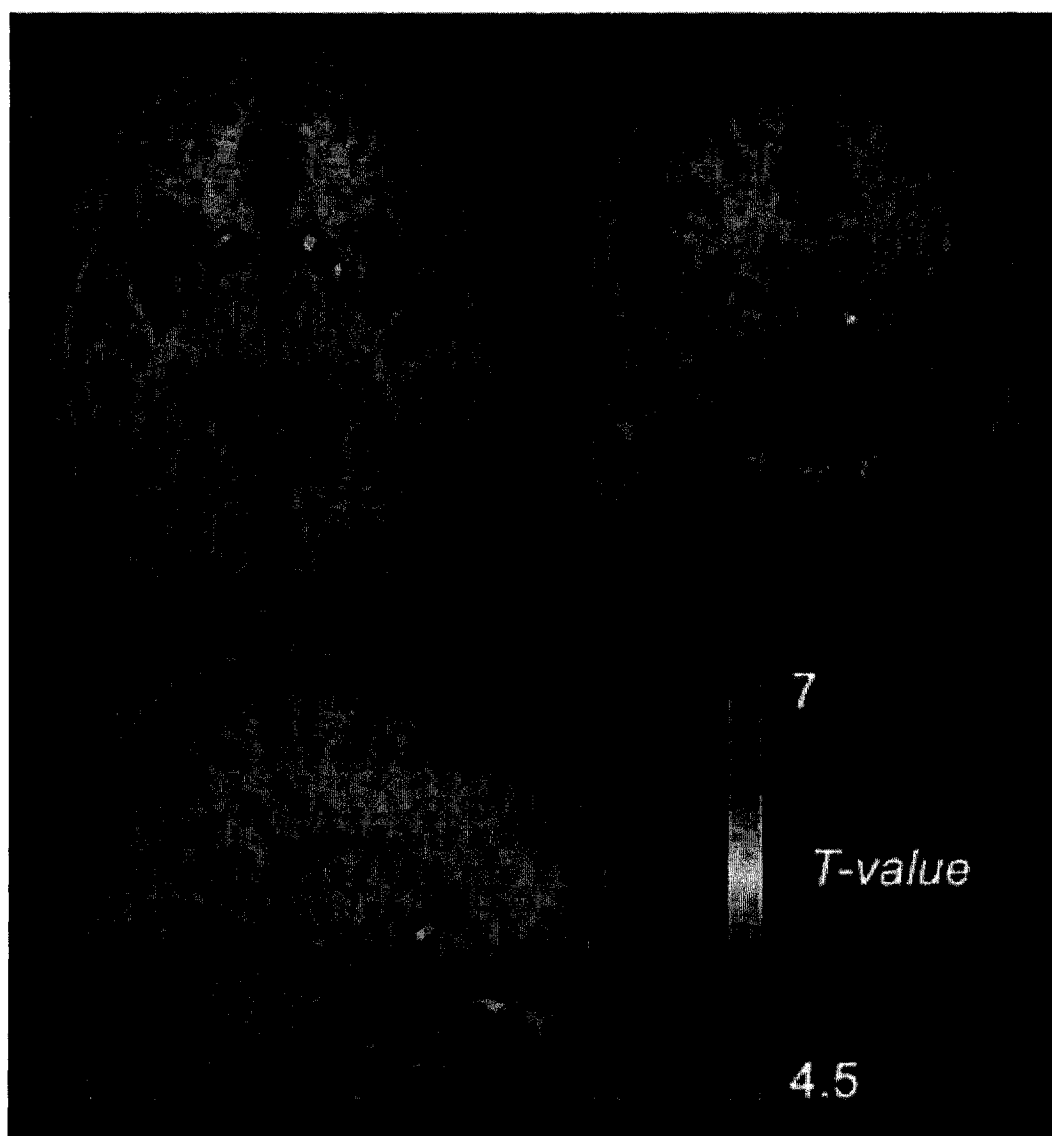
Statistical *t*-map of the change in [¹¹C]raclopride BP induced by an acute oral dose of alcohol (1 ml/kg) in healthy volunteers (n=6). Colour clusters superimposed on the average MRI from all subjects depict a significant change in BP in the ventral striatum.
